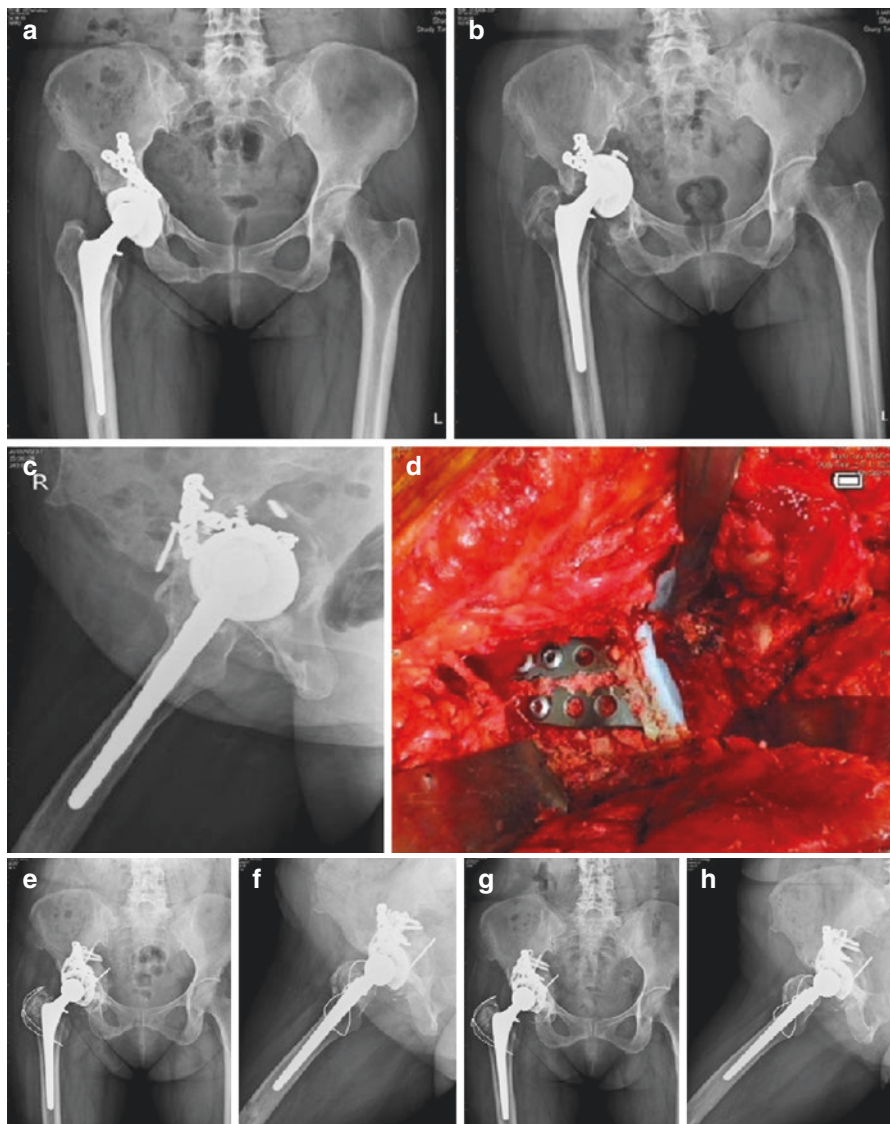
A 40-year-old woman sustained a fracture-dislocation of the right hip complicated with posttraumatic arthritis S/P right THA in 2003 (a). Twelve years later, aseptic loosening of the right THA with Paprosky type IIIIB acetabular defect including severe superoposterior and medial wall segmental bone loss was noted (b and c). Intraoperative picture showed cage reconstruction in conjunction with structural and morselized allografts for acetabular defects (d). Three months after revision of THA, the radiographs showed partial consolidation of the grafts and well-fixed cage fixation (e and f). Two years after the operation, the radiographs showed improved consolidation of all the allografts and no loosening of the cage or broken screws (g and h) (these pictures were agreed by the patient for publication)
